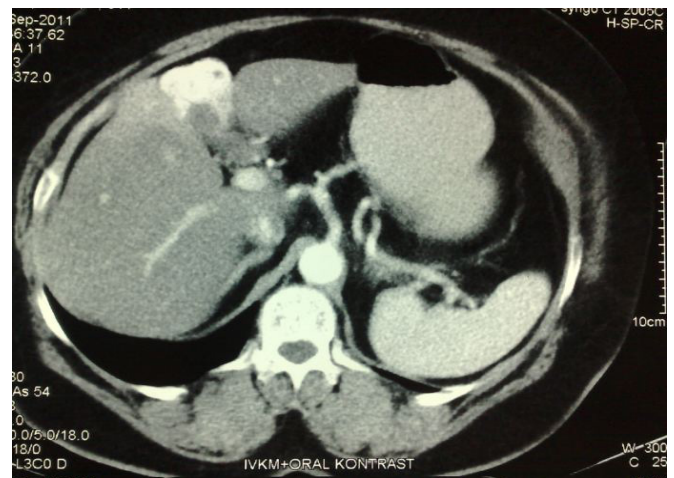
A 3.5x2.5 cm in size, irregular shaped, solid mass in the gallbladder was observed on contrast enhanced CT scan of the abdomen.
